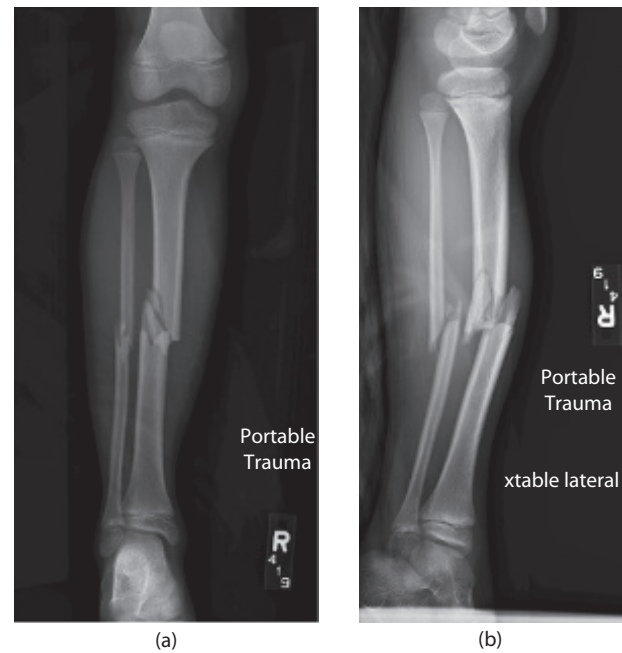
(a) and (b) Radiographs of an 8-year-old male who sustained a comminuted tibial shaft fracture when he was struck by a car while riding his bicycle.
